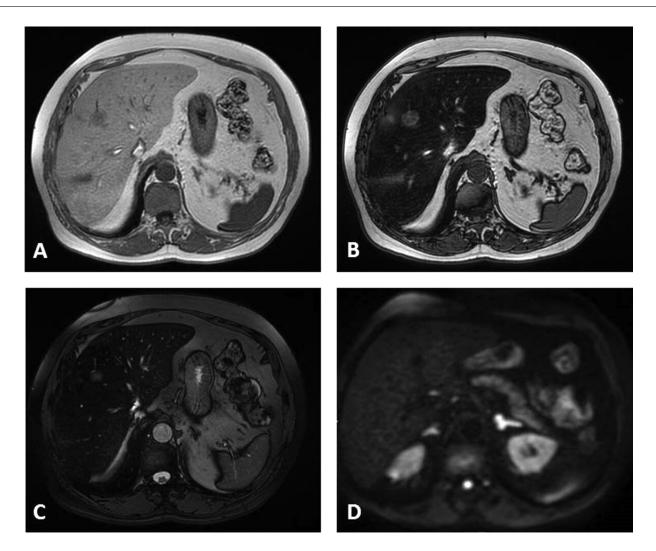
At unenhanced MRI the nodule in segment VIII was isointense to liver parenchyma on T1- "in phase" (A) and "out of phase" (B) sequences, slightly hyperintense on T2- (C) and nearly isointense on diffusion weighted images (D). The nodule in segment VII showed some morphologic characteristics.
